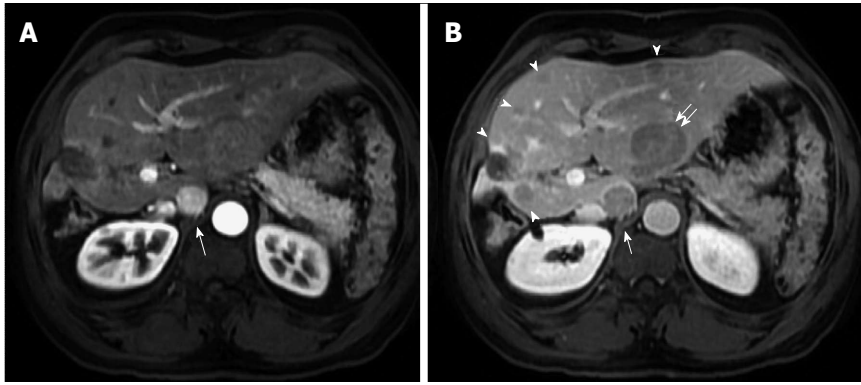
Hypervascular and non-hypervascular hepatocellular carcinomas. Post contrast fat-suppressed 3D-GRE T1-weighted images during the (A) late hepatic arterial and (B) delayed phases. There is a focal hepatic lesion medial to the inferior vena cava, which demonstrates intensely increased arterial enhancement (arrow, A) and washout on delayed images (arrow, B) in keeping with a hypervascular HCC. Additionally, there are multiple foci of delayed washout throughout the liver (arrowheads, B), the largest of which is seen at the left hepatic lobe (double-arrow, B), with variable degrees of arterial enhancement, in keeping with multiple hypo- and iso- vascular HCCs. Of note are the hypertrophic changes of the left hepatic lobe as well as atrophic and post-interventional changes of the right hepatic lobe. HCC: Hepatocellular carcinoma; GRE: Gradient recalled echo.
